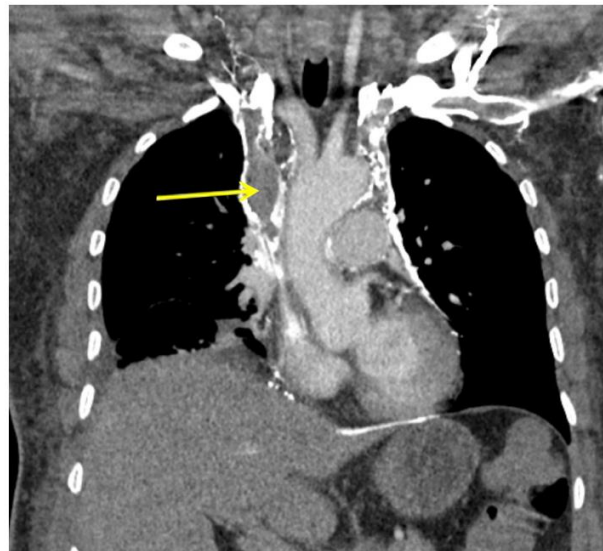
CT Thorax coronal view: yellow arrow showing the thrombus in the superior vena cava
